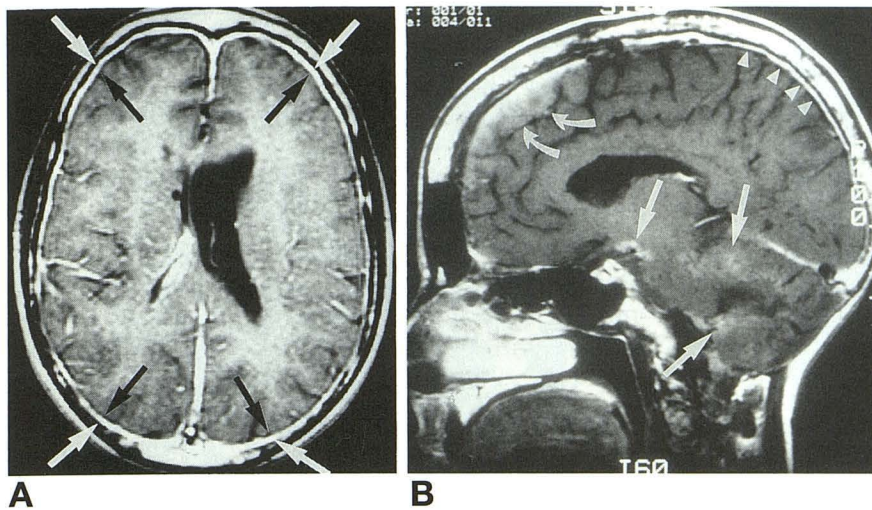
MR image of a 20-year-old man obtained 10 years after surgery.
